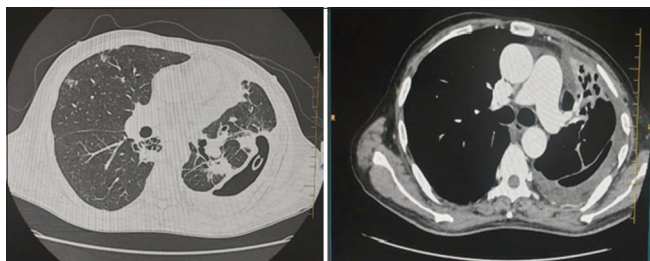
Contrast-enhanced computed tomography scan thorax (19/1/22).
